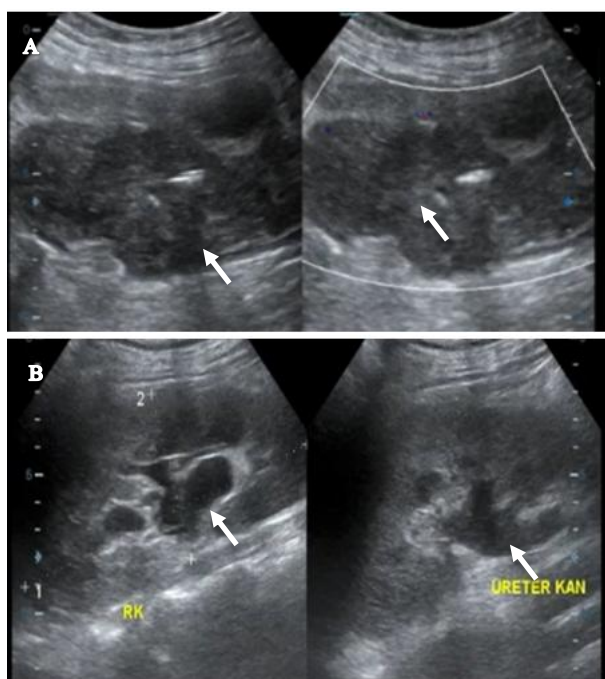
Abdominal ultrasound a) hypoechoic mass in the cervix extending into the uterus (white arrow); b) accompanied by hydronephrosis (white arrow)
